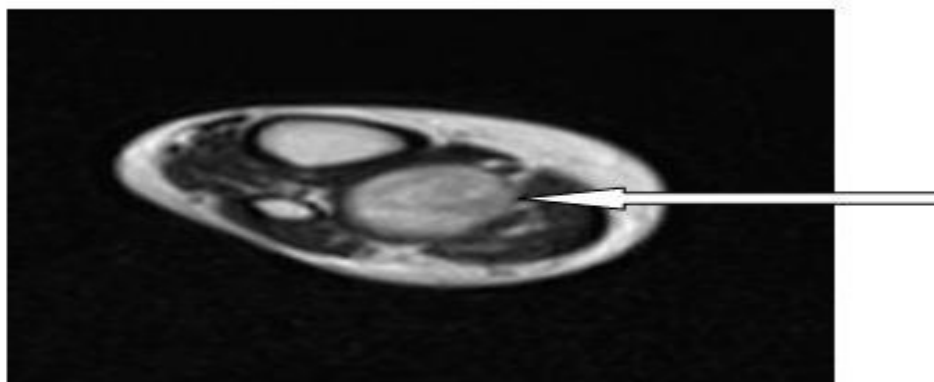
Axial Plain MRI showing circumscribed lesion along tibial nerve
